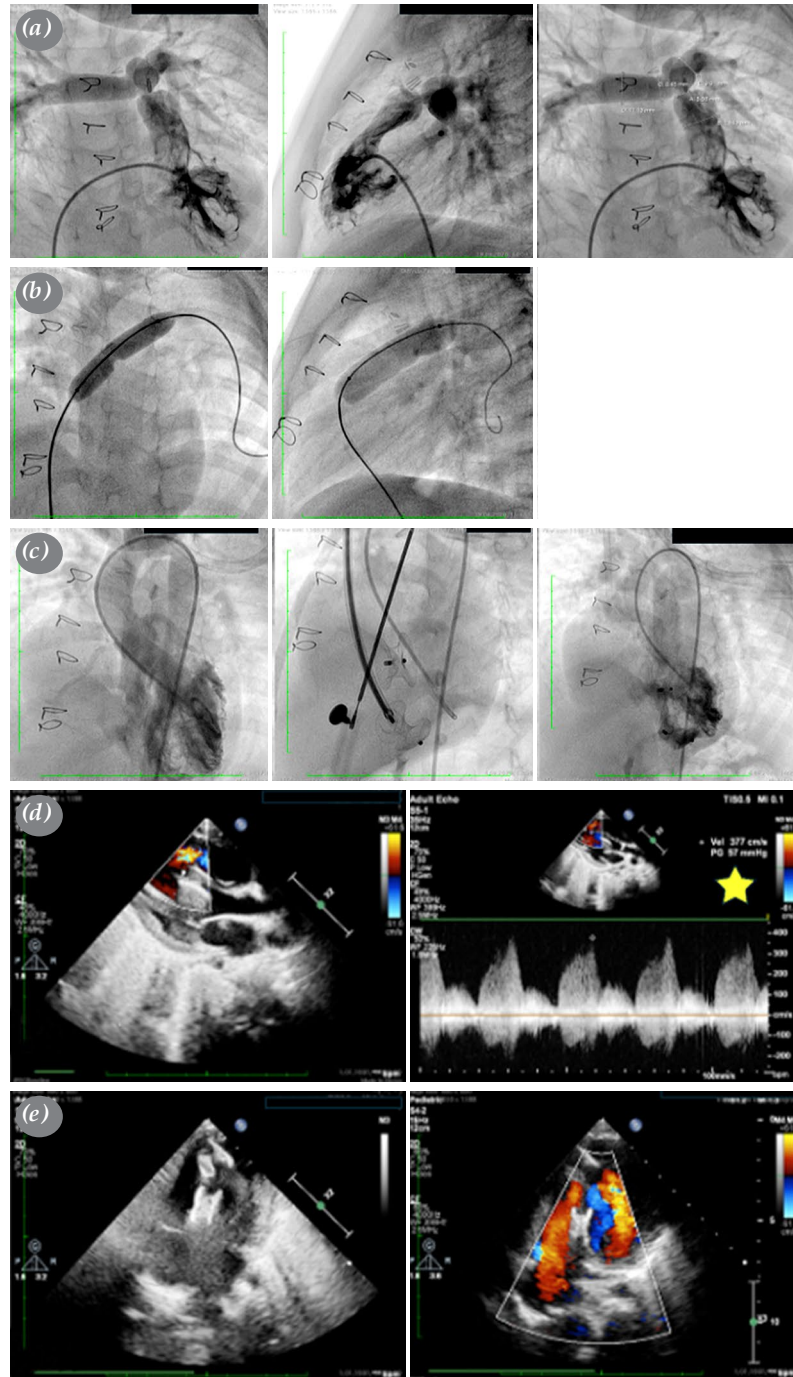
Catheter angiography was performed on a two-year-old girl weighing 12 kg due to hypoxia. (a) Tight PAB was shown during right ventricular injection after hemodynamic studies. (b) Pulmonary artery debanding was performed by applying dilation with 10- and 12-mm Z-Med balloons. (c) After visualizing muscular and apical VSDs during left ventricular injection, two 12-mm Amplatzer muscular devices were used to close them through the jugular vein. (d) Residual VSD was observed on echocardiographic examination after the procedure. It was a restrictive defect and a continuous wave Doppler gradient of 52 mmHg was obtained (yellow star). (e) On the echocardiographic examination at the last follow-up, the residual VSD was observed to have spontaneously closed.
